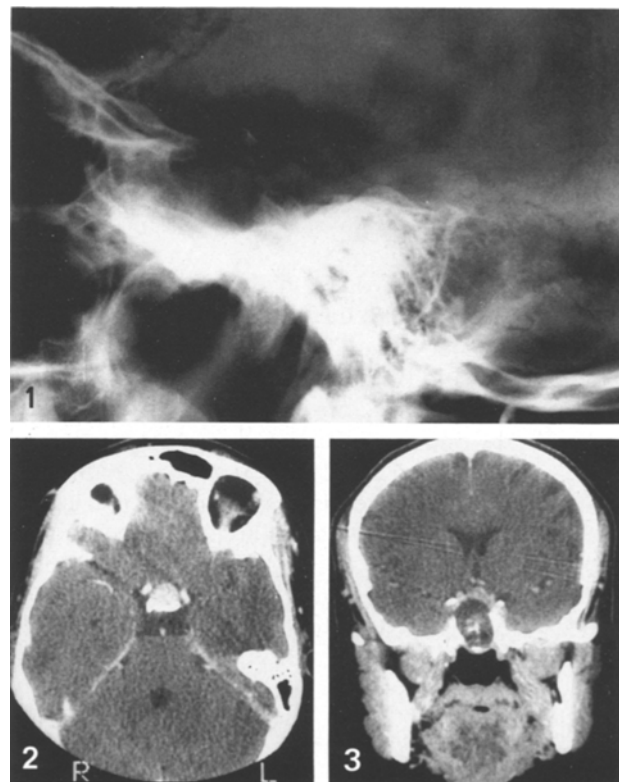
Skull X-ray film showing an enlarged sella turcica with erosion of the floor
